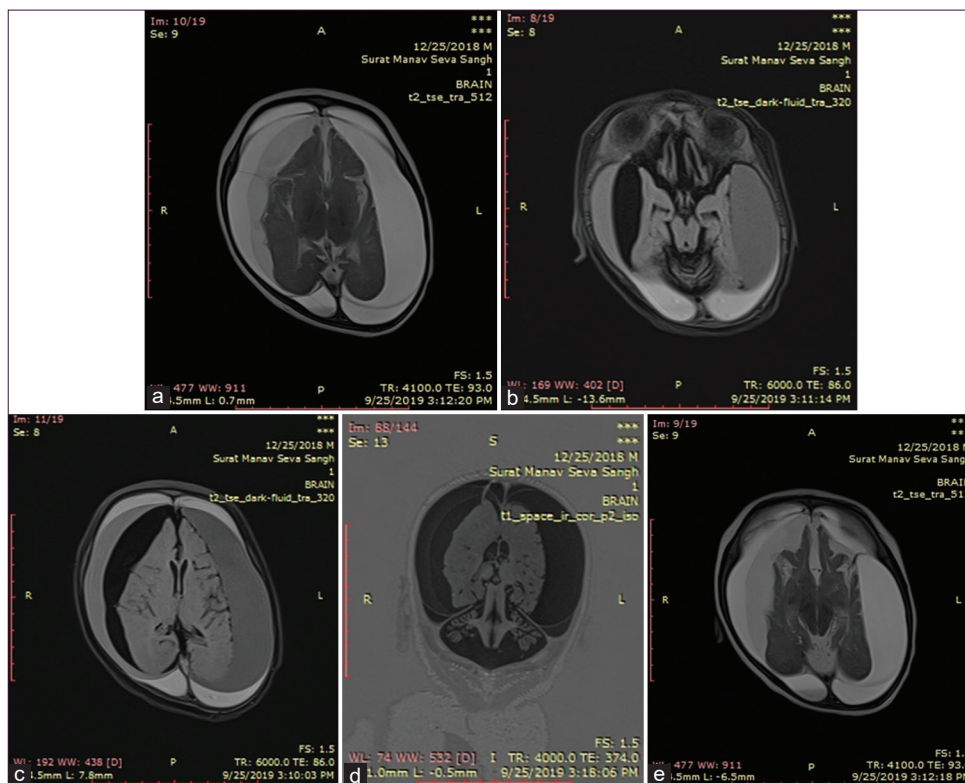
T2 and FLAIR axial (a-c and e) and T1-IR (d) coronal images showing bilateral Subdural hemorrhages in different stages of temporal evolution, along bilateral convexities. Maximum width of the SDH measuring 25 mm. Cerebellar atrophy was seen, as seen on inversion recovery sequences. However, no definitive epileptogenic focus was identified. Myelination was normal for age. No e/o any blooming foci were seen on GRE images (image not shown here)
